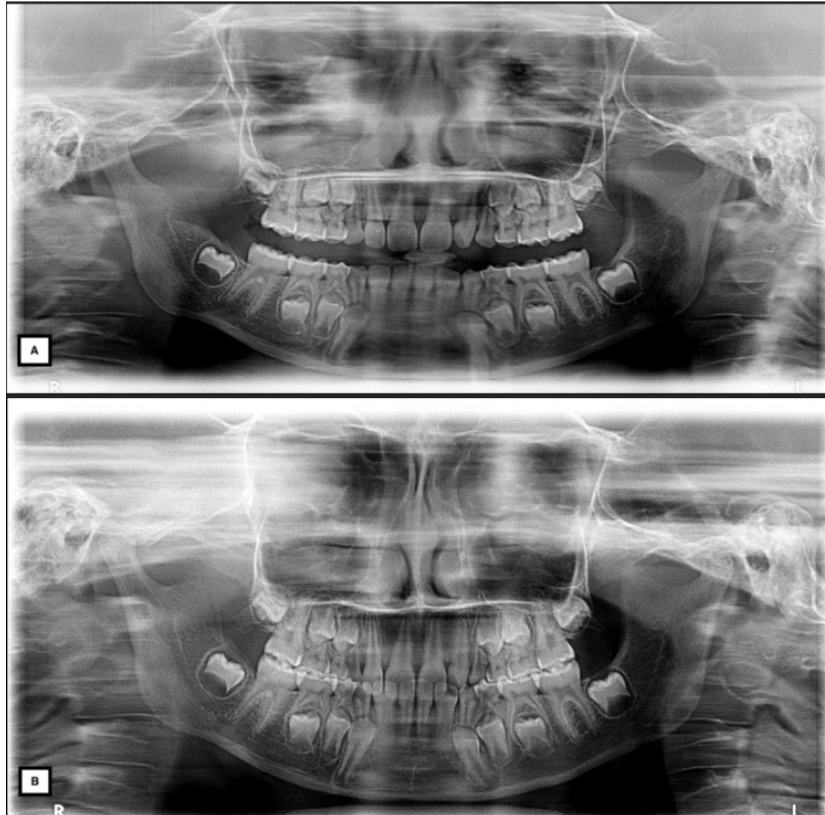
Orthopantomogram A (after completion of ATT), B (5 month after completion of ATT) showing new bone formation in the region of right coronoid process
